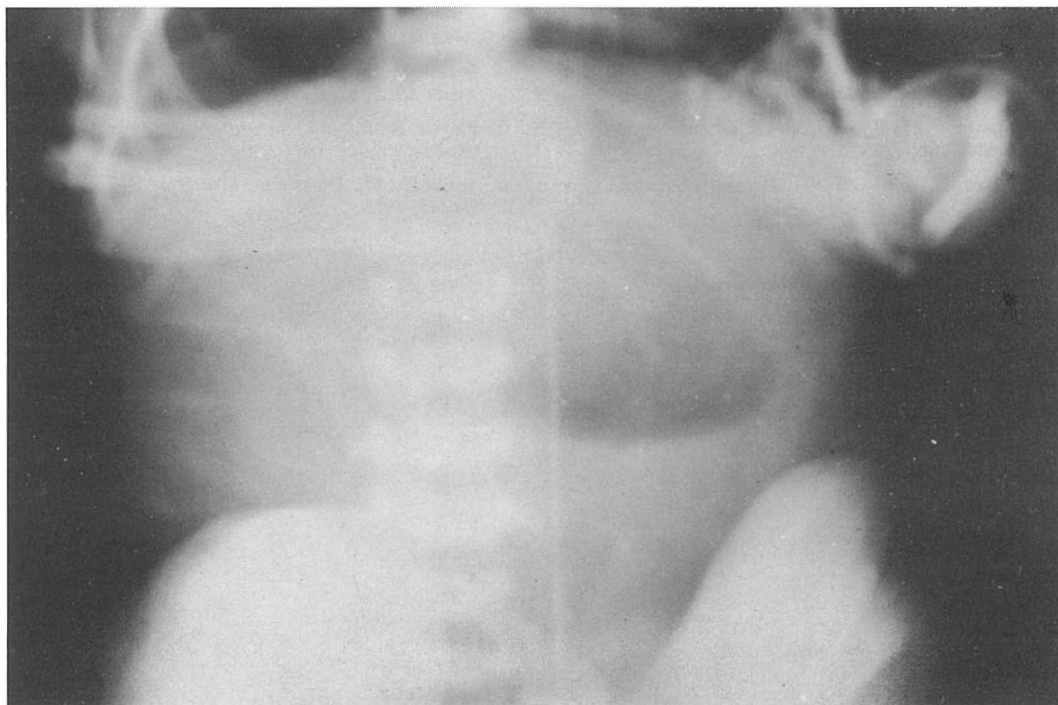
Atresia of the third segment of the duodenum. Plain film of the abdomen.
